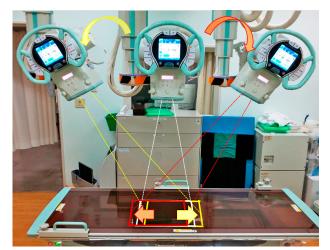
Automatic System Tracking Function Image receptor tracks the X-ray tube swing angle.
